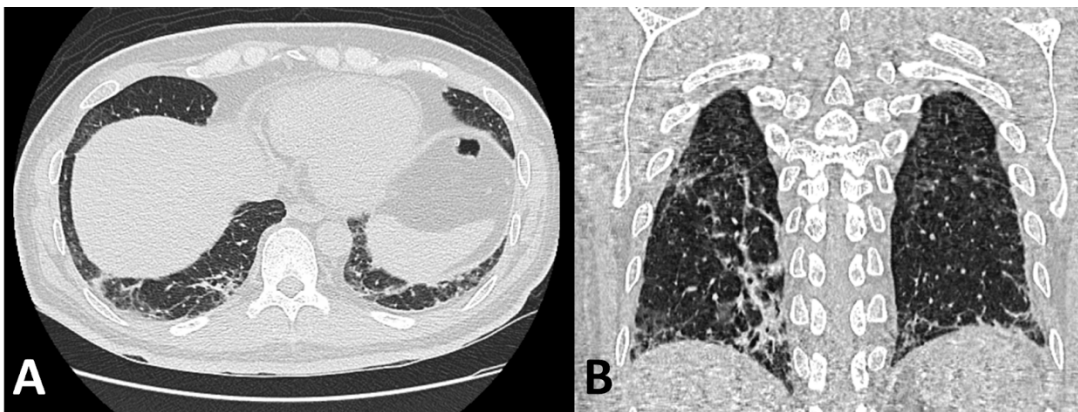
Chest CT showed bilateral lower lobe reticular pattern at (A) Coronal view (B) Sagittal view.
